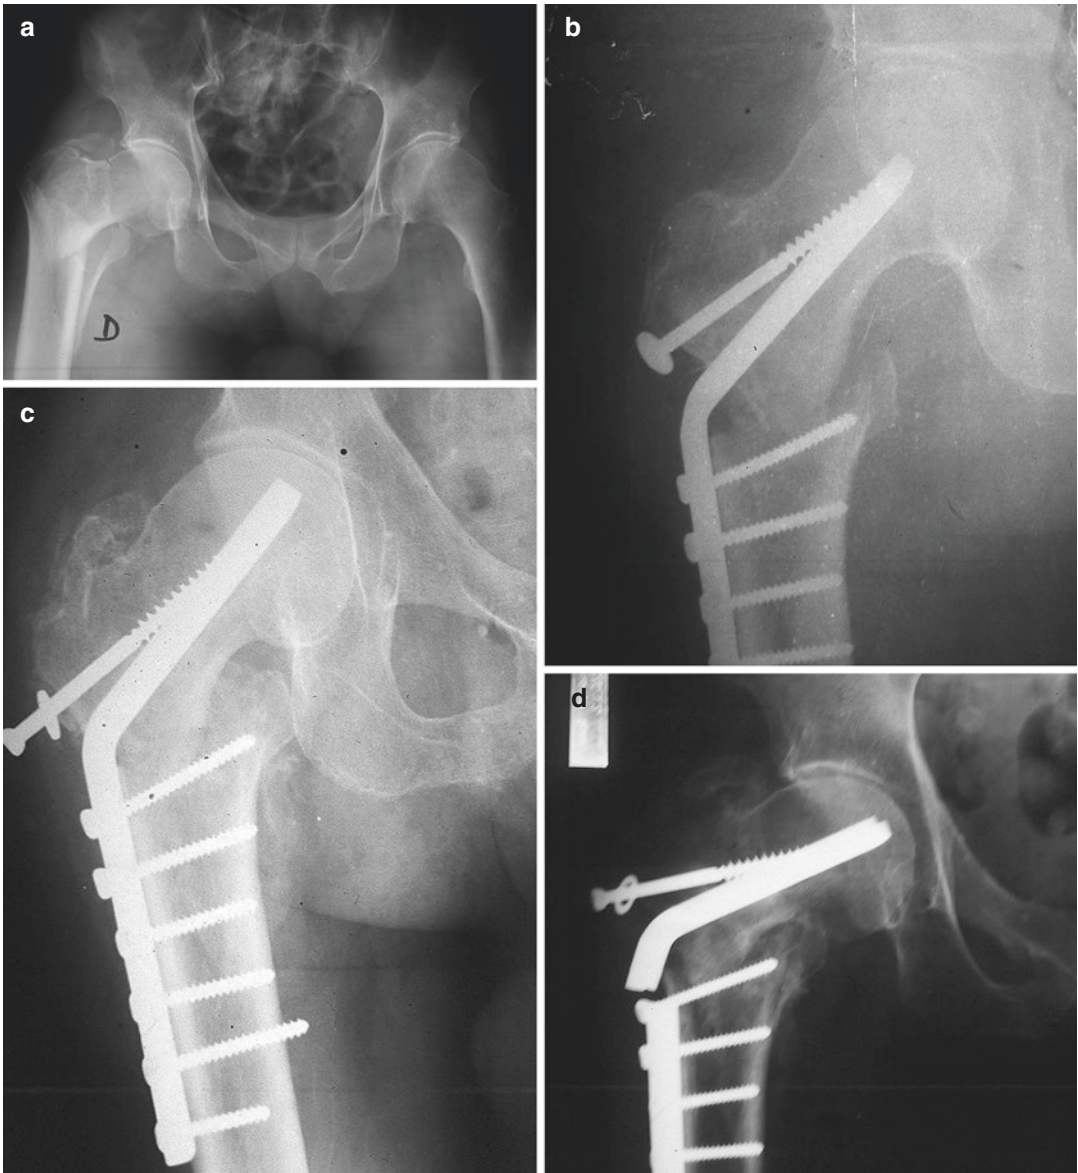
(a) X-ray of comminuted intertrochanteric fracture with posteromedial instability. (b) ORIF with blade plate and medialization of distal fragment (Dimon-Hughston). (c) The blade plate allows for only limited
